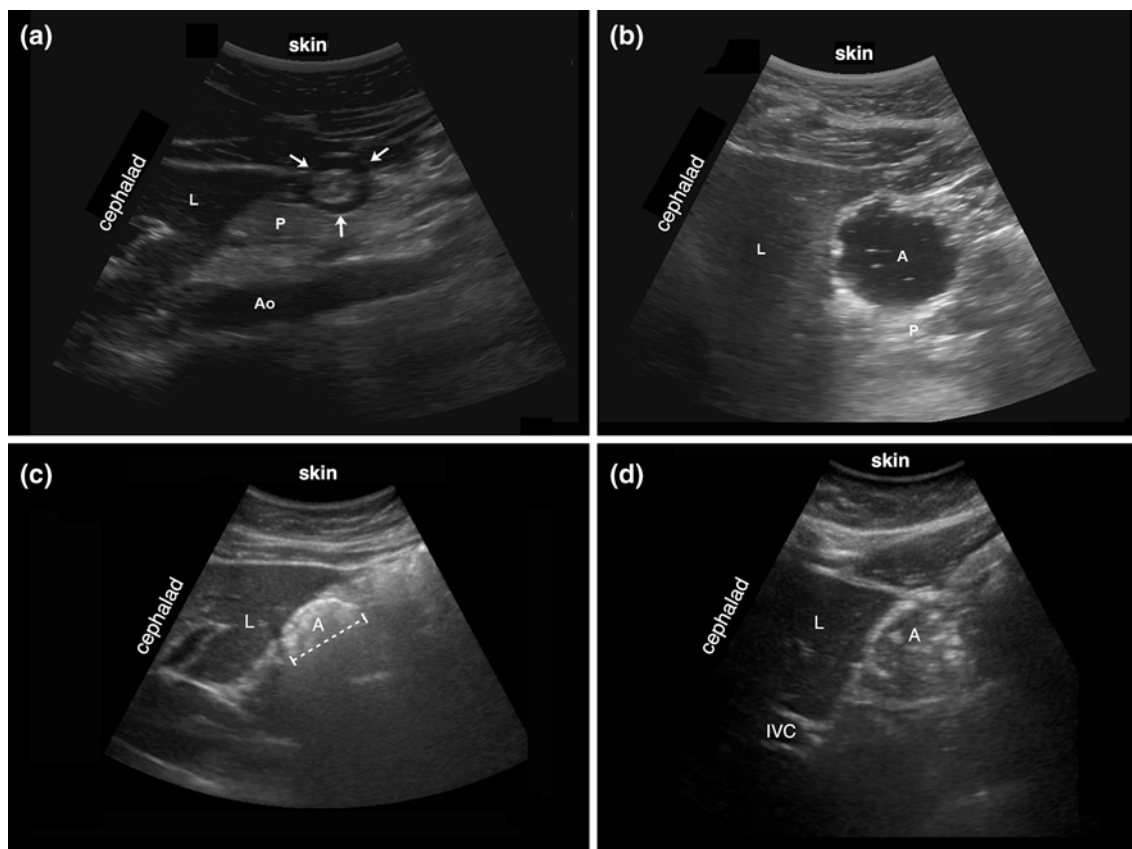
Sonographic images of the epigastric area (parasagittal plane). L = liver; A = antrum; P = pancreas; IVC = inferior vena cava; Ao = aorta. (a) Empty gastric antrum. The arrowheads denote an empty gastric antrum. The “bull’s eye” appearance is typical if the antrum is contracted. (b) Gastric antrum after 300 mL of oral fluid
